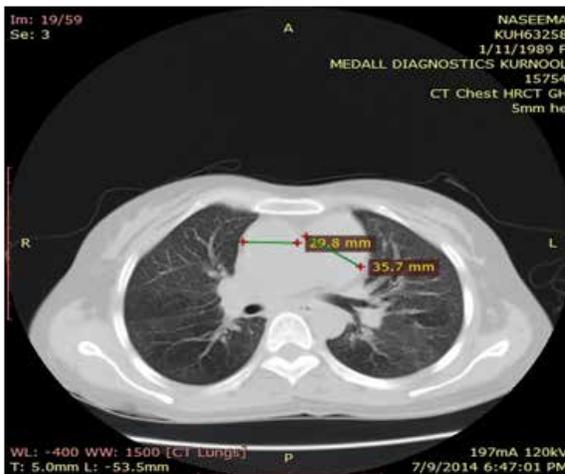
HRCT chest showing dilated pulmonary artery
